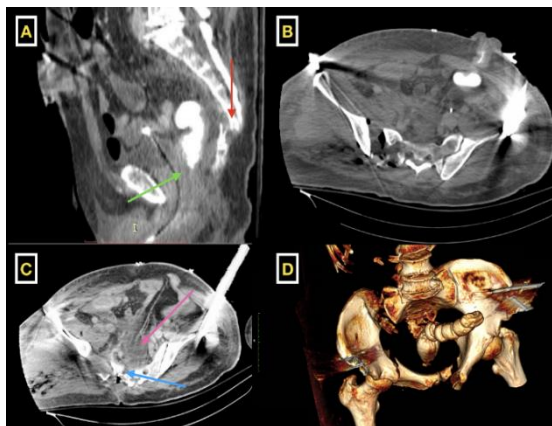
A. CT image reformatted on sagittal plane showing dislocated coccygeal fracture with anterior displacement (red arrow), cranial retraction of the anorectal stump (green arrow). B. CT image reformatted on oblique axial plane showing the distal stump of the diverting loop sigmoidostomy filled with Gastrografin, retroperitoneal haematoma, multiple complex pelvic fractures, soft tissue haematomas and free gas. C. CT image reformatted on oblique axial plane showing Gastrografin leak (blue arrow), diffuse oedema of the mesorectal fat (purple arrow), low volume haemoperitoneum and external pelvic stabilization. D. 3D Volume Rendered CT image portraying the complex and extensive pelvic fractures which resulted in unstable pelvis and external stabilization metalworks.
